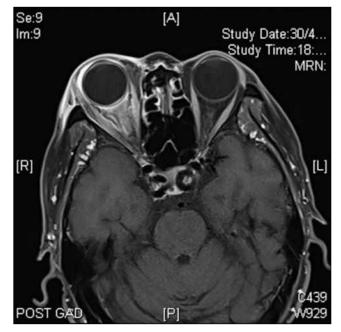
T1-weighted magnetic resonance imaging of the brain and orbit showing proptosis of the right eye with heterogenous enhancement in the intraconal space and thickened optic nerve. Sclerochoroidal complex and extraocular muscles are also thickened. The eyelid and preseptal fat enhance abnormally.
